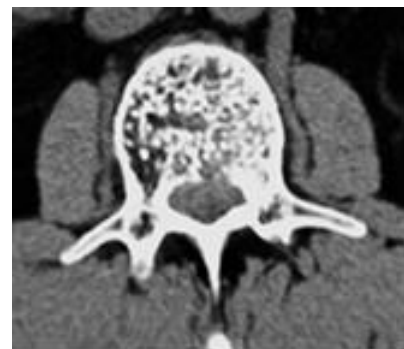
CT image of hemangioma
